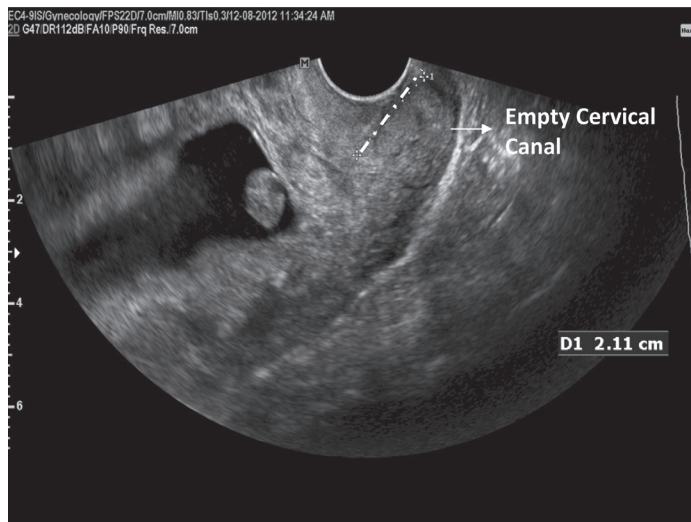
Transvaginal sonogram showing an empty cervical canal.
